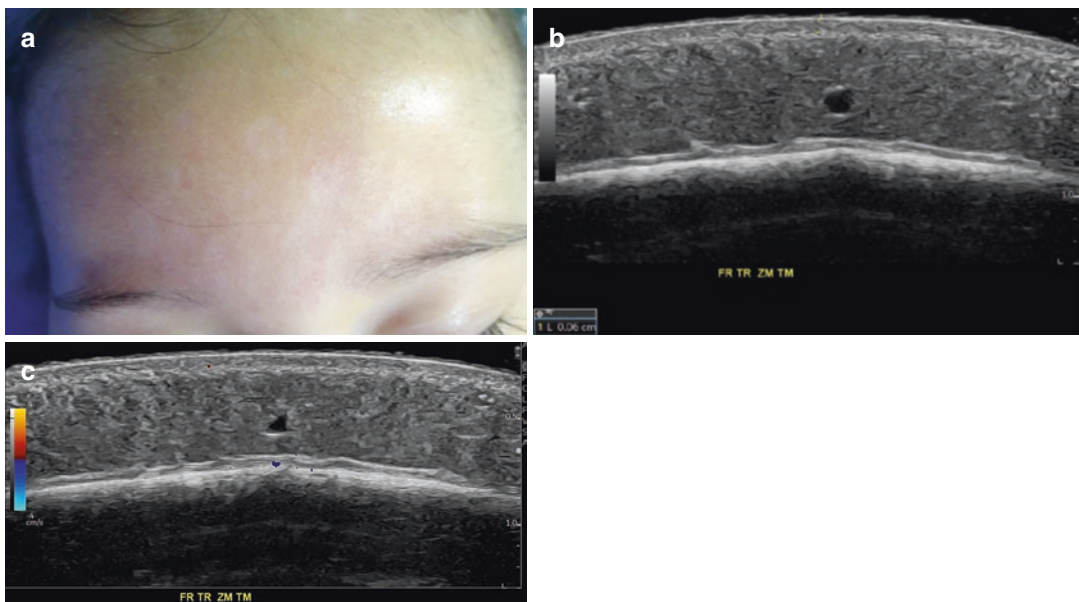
Low-flow capillary vascular malformation. (a) Clinical image. (b) Grayscale ultrasound (transverse view) of the frontal region presents slight dermal hypoechoogenicity. (c) Color Doppler ultrasound shows no signs of hypervascularity
